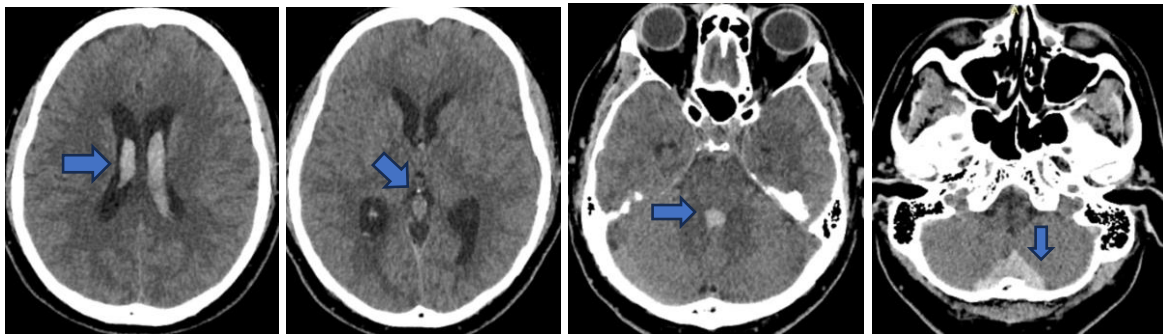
CT scan showed intraventricular haemorrhages at third and fourth ventricle causing obstructive hydrocephalus and subarachnoid haemorrhage.
